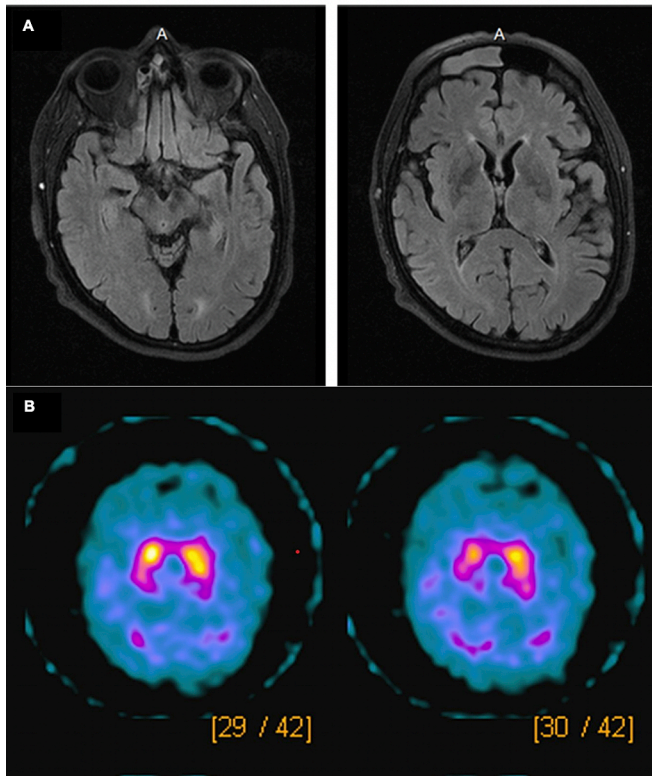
(A) Axial FLAIR imaging one year prior to presentation. Mild white matter changes and mild generalized atrophy. The MRI does not show midbrain atrophy or striatal abnormalities. (B) DaTscan with heterogeneous striatal binding and partial loss of normal comma-shaped morphology bilaterally consistent with a presynaptic dopaminergic deficit.
